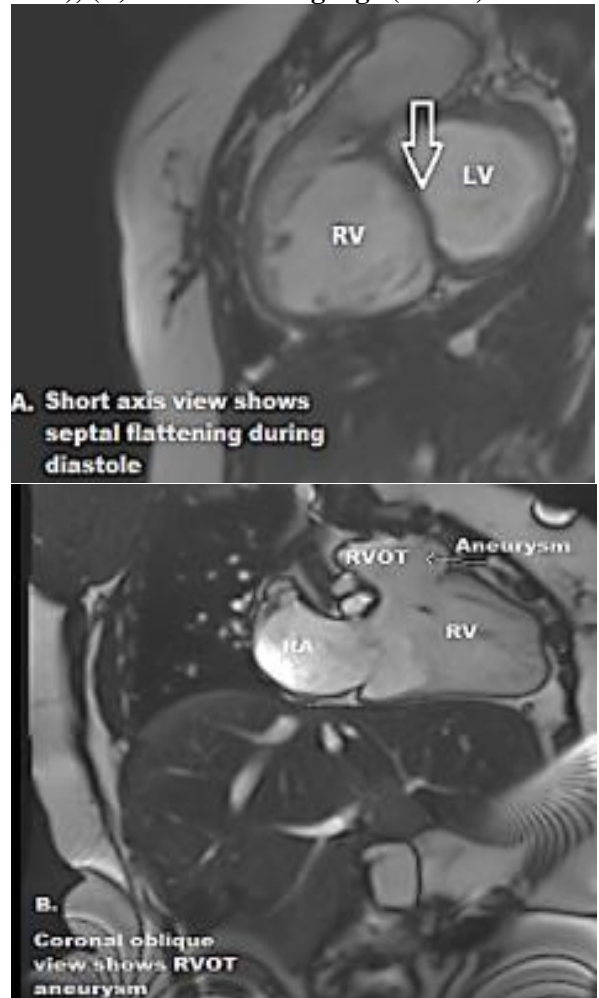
MRI study (A) short axis view of both ventricles shows septal flattening during diastole (arrow), (B) right ventricular 3-chamber view shows RVOT aneurysm (arrow).
